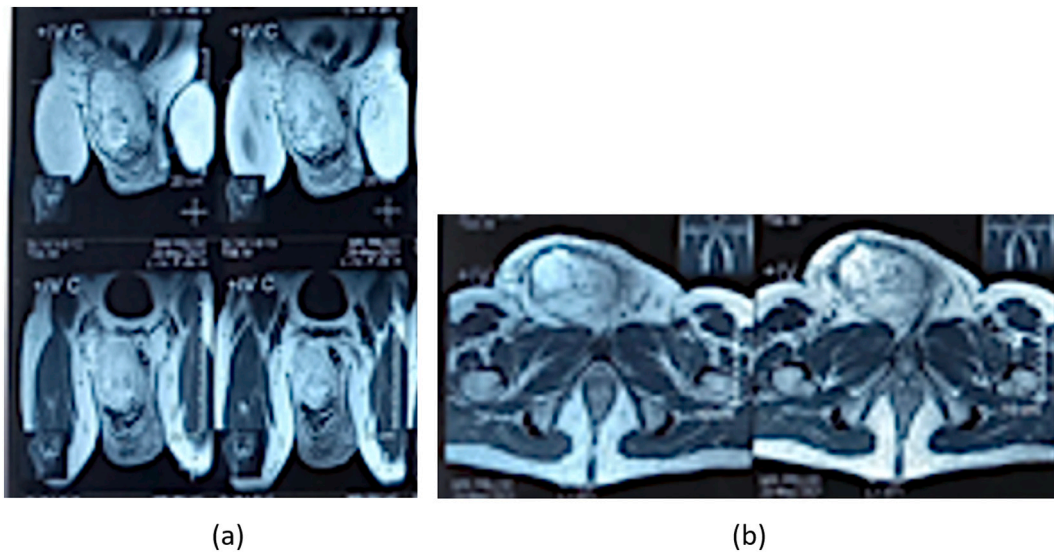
Imaging of Magnetic Resonance Imaging with the contrast of the lower abdomen. (a) frontal view (b) sagittal view. A right intrascrotal mass was found with a clear margin sized $7,5 \times 9,4 \times 14,9$ cm that compressed the testicle inferiorly.
